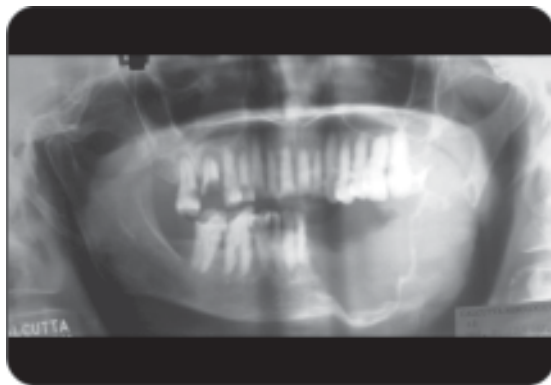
Radiographic view of neurolemmoma
